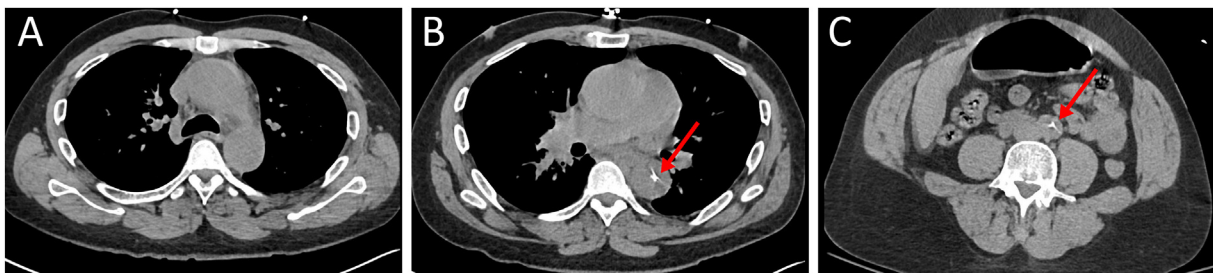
Non-contrast Computed Tomography demonstrating subtle findings suggestive of Aortic Dissection. Evidence of aneurysmal dilation of the proximal ascending aorta (A), ongoing aneurysmal dilation with a noted displaced calcified intimal flap/intraluminal high linear density in of the thoracic descending aorta (B) and distal abdominal aorta (C).
